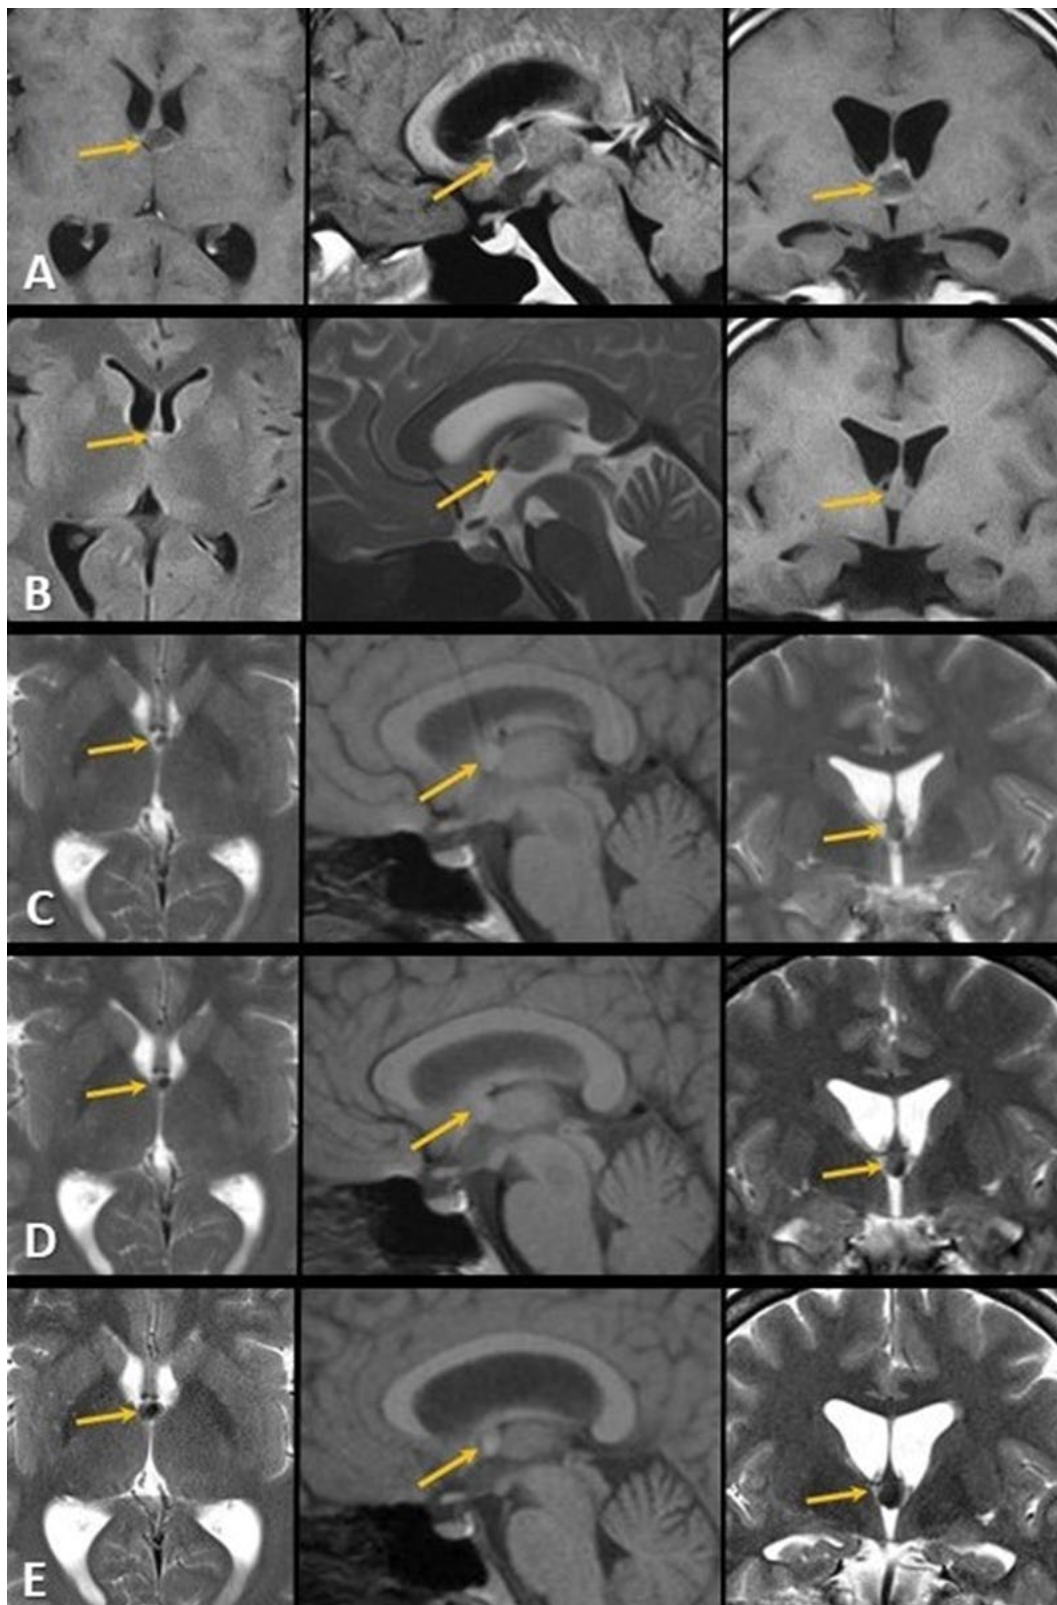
Chronology of colloid cyst III ventricle changes on T1, T1 + C, T2 MRI. (A) Primary MRI T1 + C, 2012. The yellow arrow shows a two-component (dense component in the lower part, more liquid on top) colloid cyst of ventricle III with contrast accumulation in the form of a thin rim around the cyst (contrasting of the septal veins adjacent to the cyst), MAX size 14 mm; moderate ventricular dilation (EI = 0.28); (B) Control MRI T1, T2 after TBI, 2012. Dense colloid cyst component (yellow arrow), MAX size 5 mm; mild ventricular asymmetry (D ≥ S) (EI = 0.24); (C) Follow-up MRI T1, T2, 2013. Dense colloidal cyst component with a small accumulation of colloidal masses (yellow arrow), MAX size 6 mm; IE = 0.25; (D) Follow-up MRI T1, T2 2015. Dense colloidal cyst component with increasing accumulation of colloidal masses (yellow arrow), MAX size 7 mm; IE = 0.26; (E) Follow-up MRI T1, T2 2021. Dense colloid cyst component with increasing accumulation of colloidal masses (yellow arrow), MAX size 8 mm; EI = 0.27.
